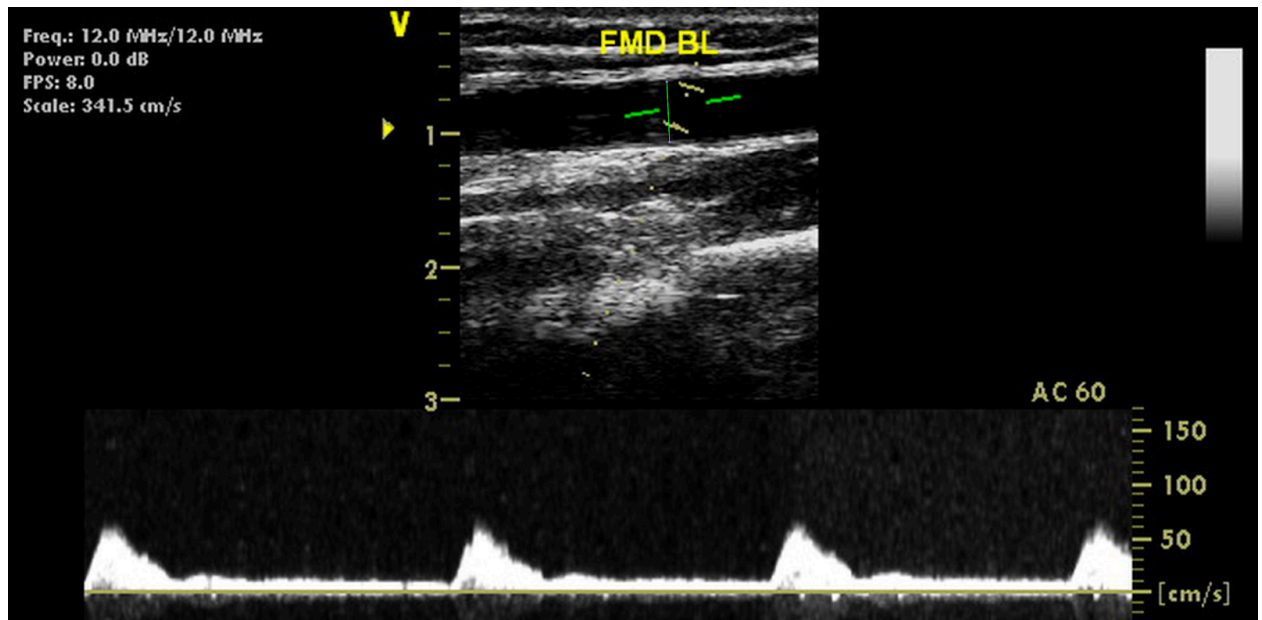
Representation of Duplex Mode on Vivid I ultrasound, with collection of vessel diameter (top) and blood flow velocity (bottom) taken at baseline, over 20 seconds. Scale is blood flow velocity in cm/s. AC 60 is the insonation angle.
